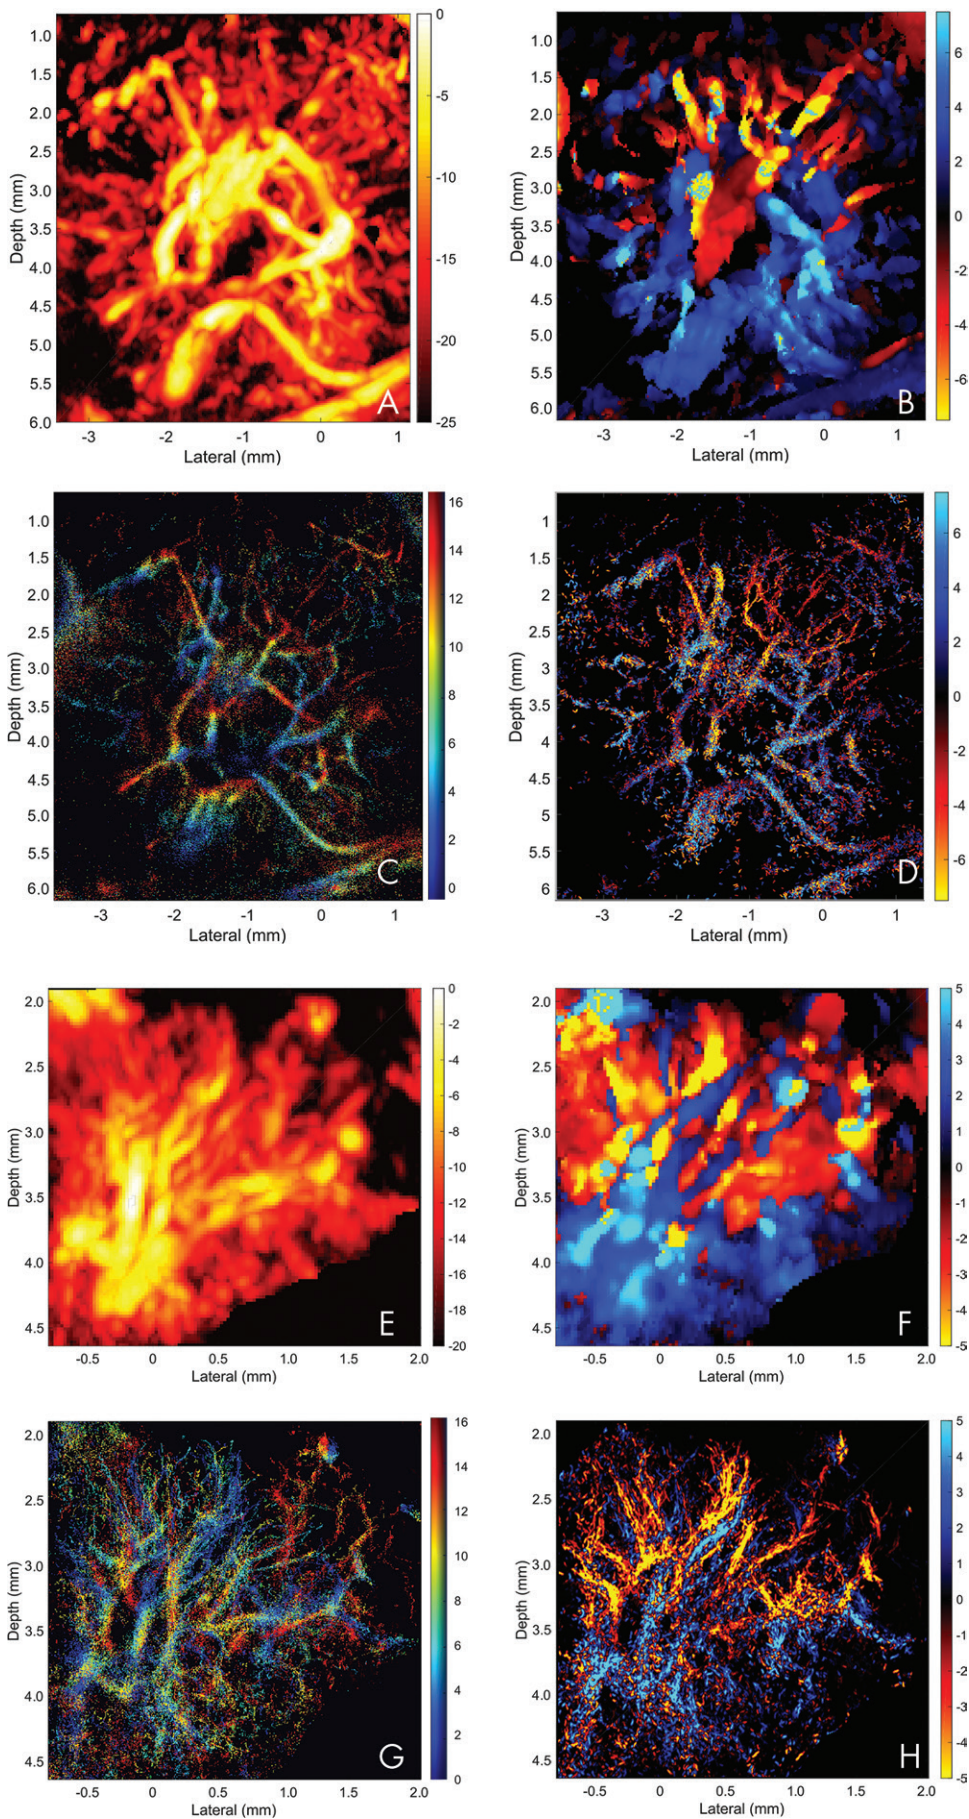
(continued): and D, E, ASAP-enhanced color Doppler images. Top and bottom groups of images were obtained from two different lymph nodes.
